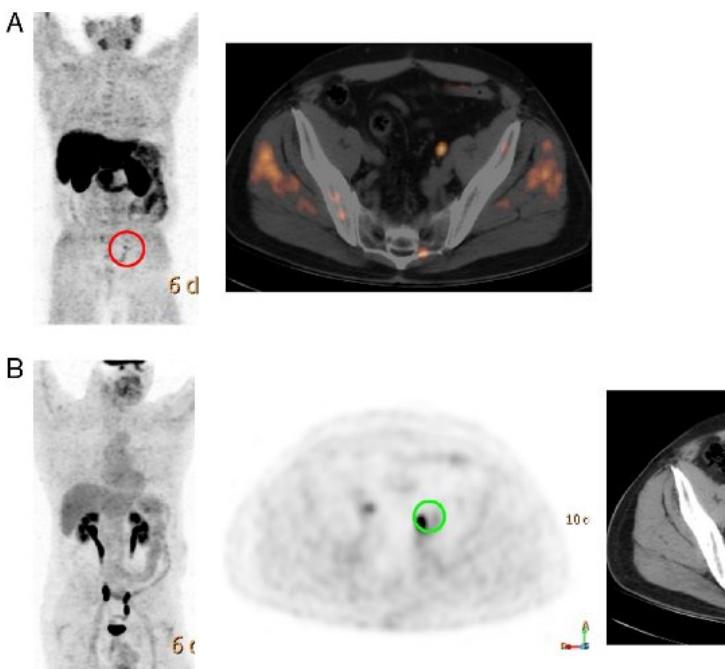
^{11}C -choline PET CT shows prostate cancer recurrence within the left iliac lymph node.
